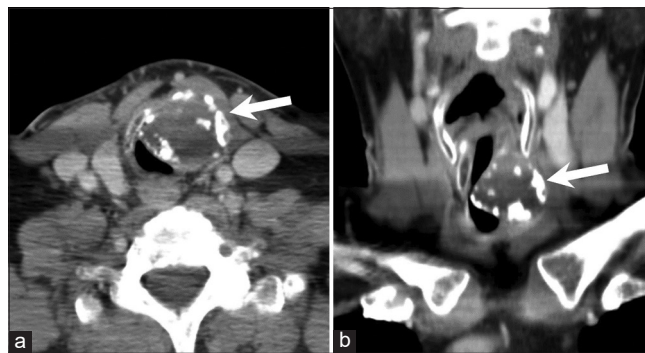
Laryngeal chondrosarcoma. A 59-year-old man with laryngeal chondrosarcoma presenting with progressive hoarseness of voice. Axial (a) and coronal-reformatted (b) contrast-enhanced CT images show an expansile partially calcified mass arising from the left lateral aspect of the cricoid cartilage (arrows), severely narrowing the airway. Note characteristic chondroid matrix calcification within the tumor.
